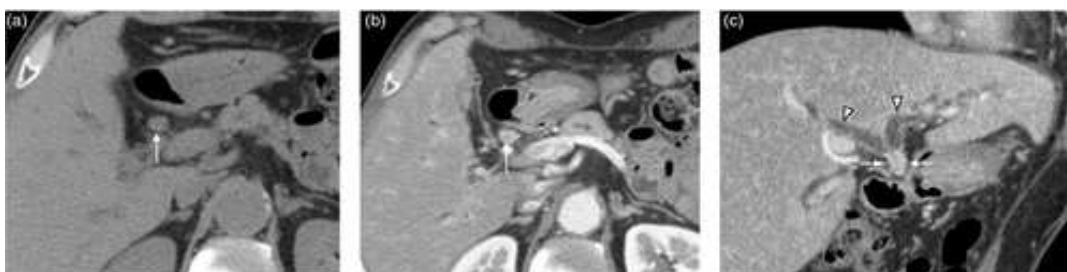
Extrahepatic bile duct cancer. (a) Pre-contrast CT, (b) Early dynamic contrast-enhanced CT phase, and (c) Coronal reconstruction image (Kiryama et al, 2018).
